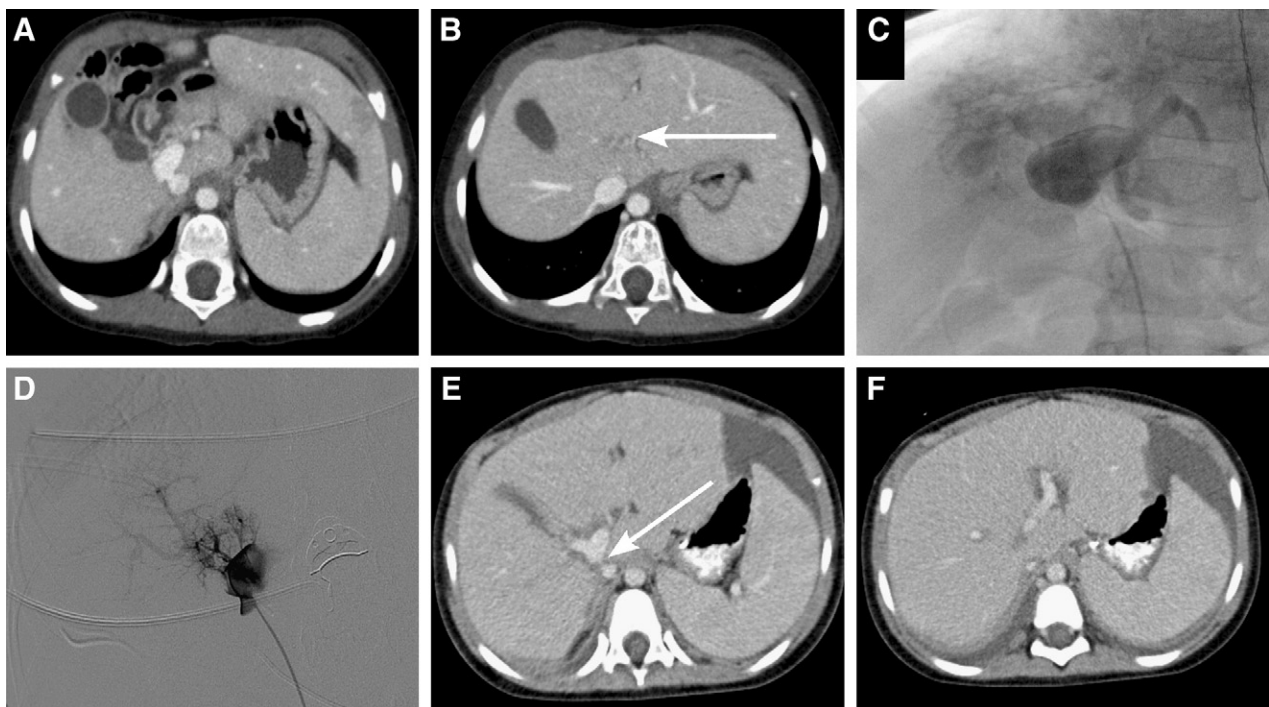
A, A type IIb portocaval fistula with a profoundly hypoplastic intrahepatic portal system is seen on preoperative CT scan. B, The intrahepatic portal branches are not visualized in their expected location (arrow). C, Intraoperative venogram demonstrates a paucity of distinct intrahepatic portal branches. D, Distinct portal branches begin appearing 2 days after shunt occlusion. Computer tomographic scan 2 weeks after surgery demonstrates the absence of a fistula in its former location (arrow) (E) and improved opacification of the intrahepatic portal branches as well as a decrease in the caliber of the IVC (F). Some ascites, as seen here, is not uncommon in the early postoperative period when there is a transient rise in portal pressure.
